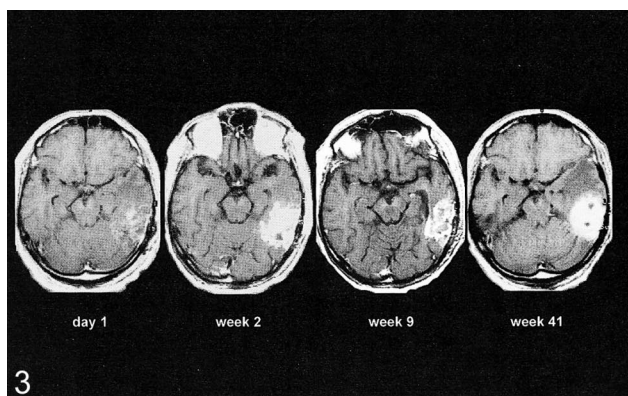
Flare enhancement and tumor relapse after complete resection. MR images obtained on day 1 and weeks 2, 9, and 41 postoperatively show development of a strong flare after resection of all enhancing tissue within the temporal lobe. There is initial regression of flare, but eventually there is recurrence of local tumor (enhanced T1-weighted axial MR images, patient 18).
